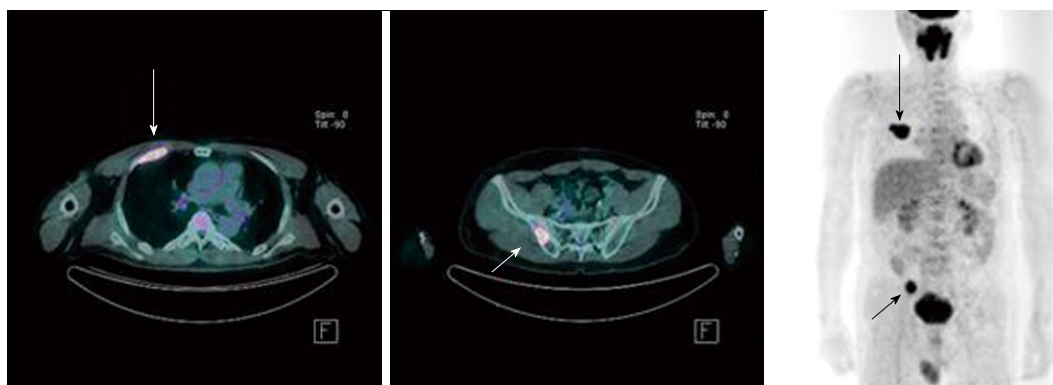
Preoperative whole body positron emission tomography computed tomography showing hypermetabolic metastatic lesions in the right third rib (long arrows) and right iliac bone (short arrows).
